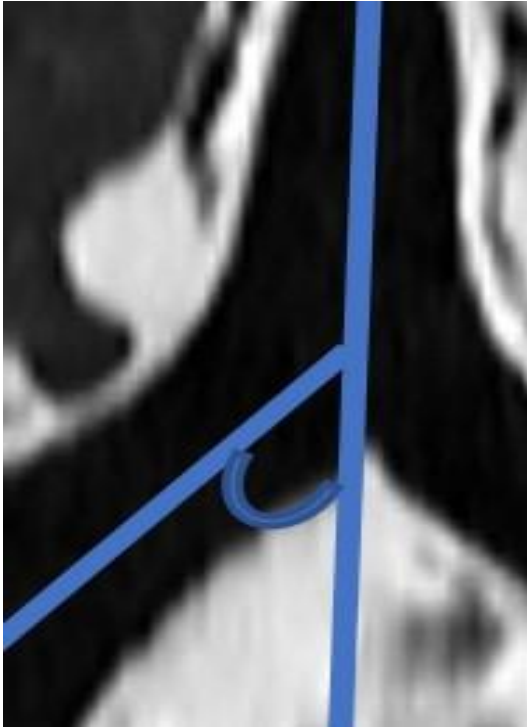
Right main bronchus angle (RMBA): The angle between a vertical line passing through the center of the trachea and a line passing through the center of the right main bronchus on a coronal reformatted CT image
